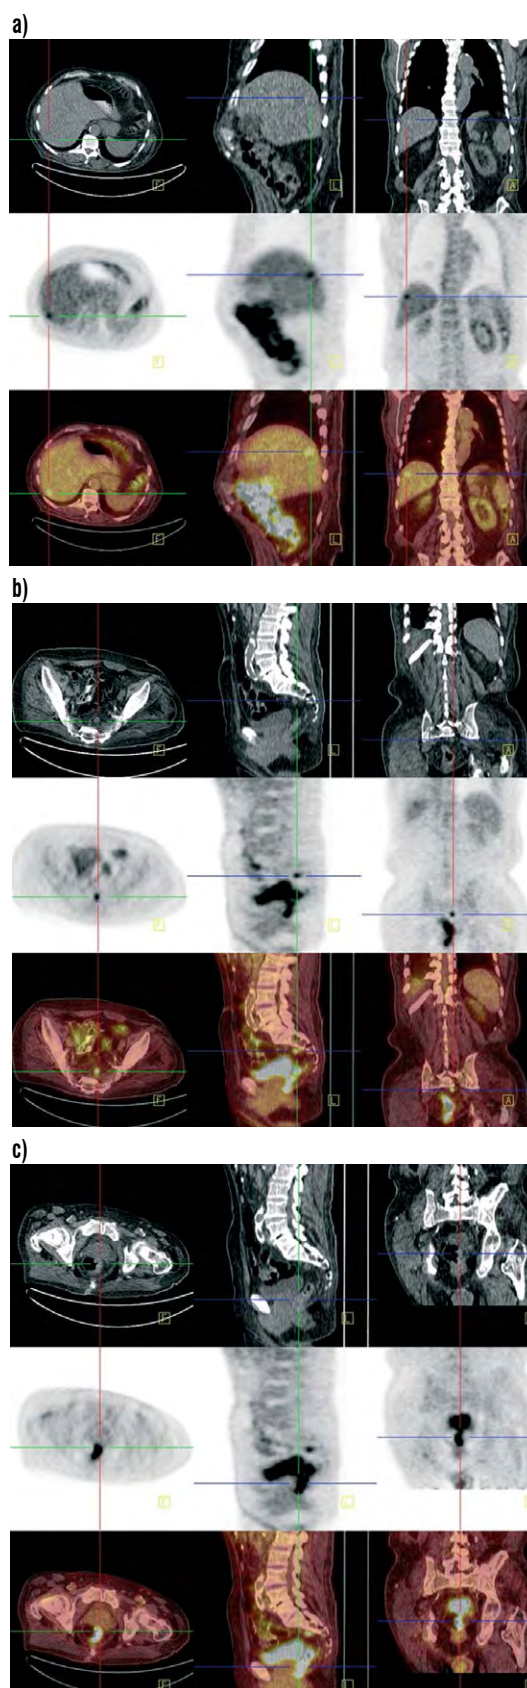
A 74 year-old male; Status post colonoscopy; biopsy detected adenocarcinoma recti a) FDG avid lesion in hepatic segment 7, SUV = 3.9, consistent with metastasis b) FDG avid presacral lymph node (on the left), SUV = 4.7, consistent with metastasis c) FDG avid focus, left lateral aspect, rectal area, SUV = 10.9, consistent with primary
